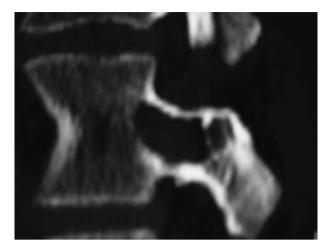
Preoperative CT-scan, sagittal view. Osteolytic lesion of the right pedicle of L2.
